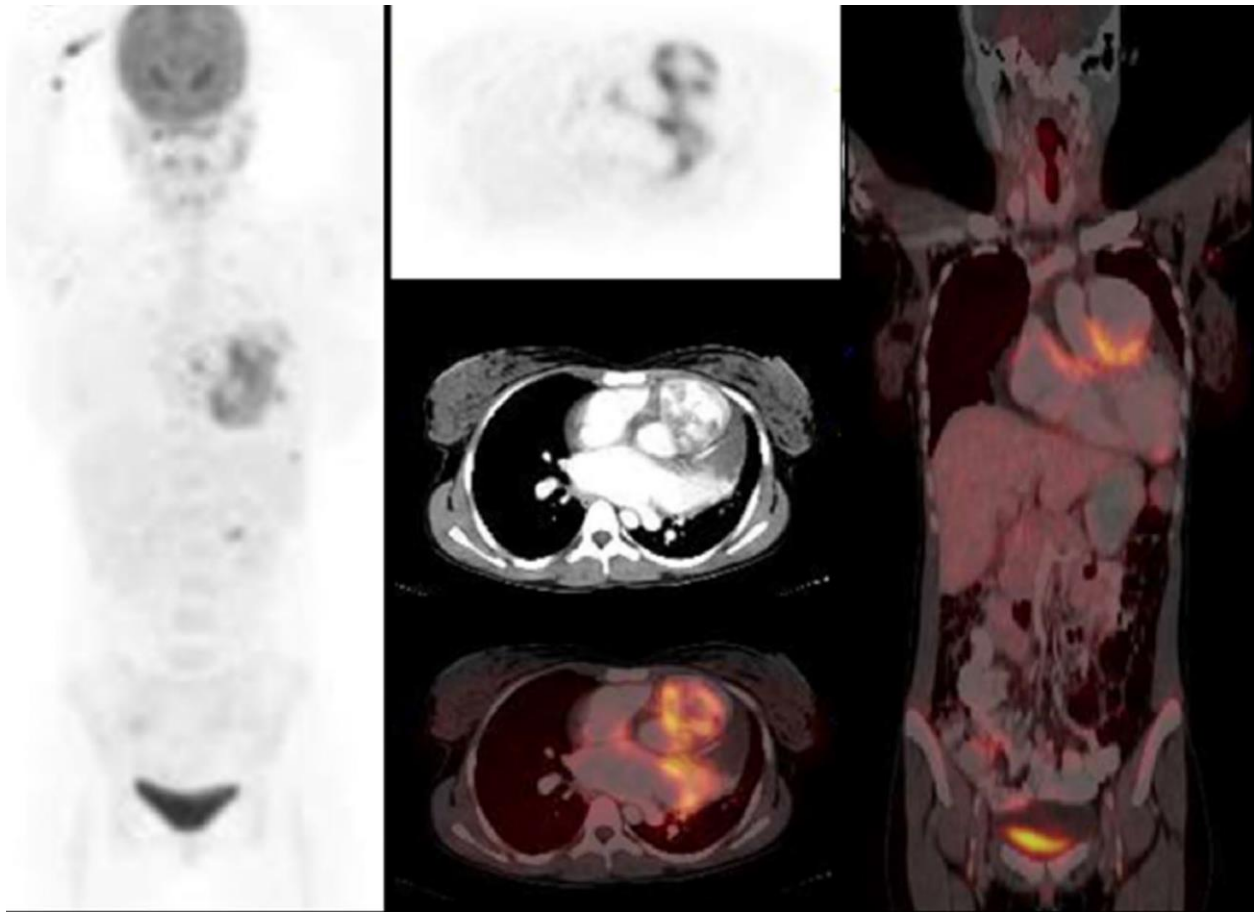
Images of a newly diagnosed HIV-infected female who had ^{18}F -FDG PET/CT to identify the cause of fever of unknown origin. Images showed intense ^{18}F -FDG uptake in the mitral valve and surrounding myocardium. The patient subsequently succumbed to her disease. Post-mortem analysis confirmed infective endocarditis on the background of rheumatic heart disease. These images demonstrate the potential utility of ^{18}F -FDG PET/CT in the evaluation of endocarditis occurring on the background of rheumatic heart disease
